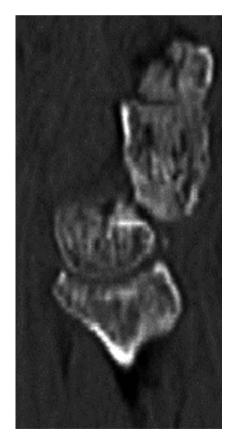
Sagittal MIP CT. SLAC 3. Arthrosis with capitolunate partial dislocation
